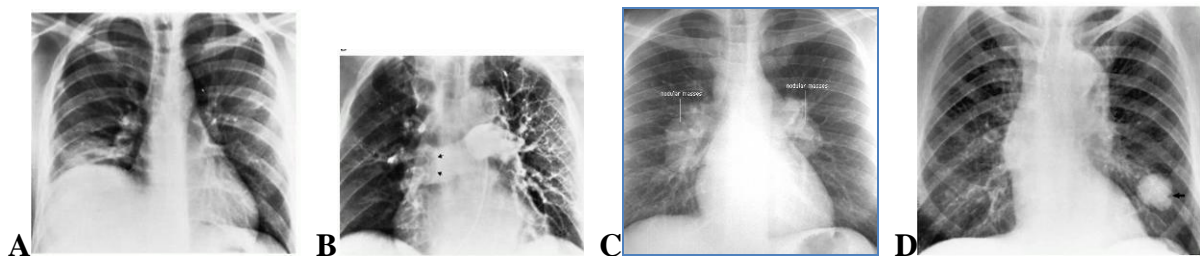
Pulmonary embolism. (A) Plain chest radiograph demonstrates right basilar atelectasis associated with elevation of the right hemidiaphragm, representing a large subpulmonic pleural effusion. (B) Pulmonary arteriogram same patient shows virtually complete obstruction of the right pulmonary artery (arrows). (C) Frontal view of the chest demonstrate marked bilateral hilar adenopathy. (D) Bronchial adenoma. Nonspecific solitary pulmonary nodule at the left base. Note the notched indentation of the lateral wall (arrow) of the mass. Although this «Rigler notch» sign was initially described as being pathognomonic of malignancy, an identical appearance is commonly seen in benign processes
